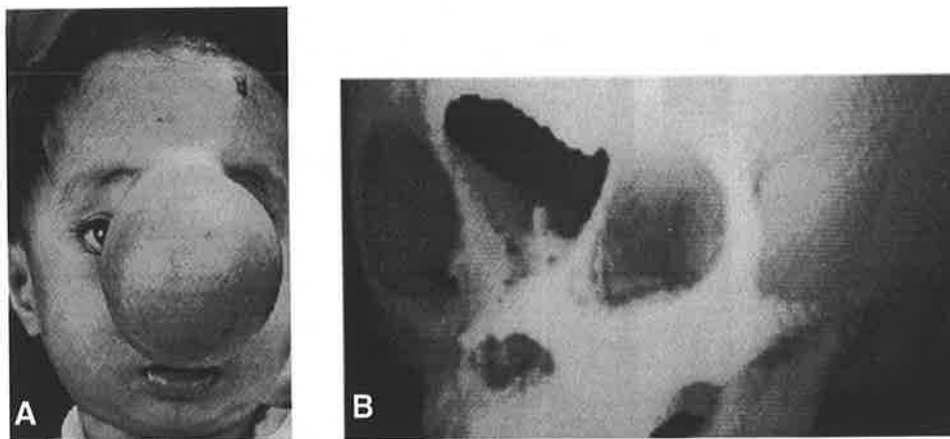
A. A large nasofrontal type of frontoethmoidal meningoencephalocele. B. Three-dimensional computed tomogram demonstrates the downward tilted cribriform plate with the crista galli forming the posterior margin of the cranial defect and the nasal bone forming the inferior margin of the facial defect. (From D. David et al. *Meningoencephaloceles: Classification, pathology, and management. Adv. Plast. Reconstr. Surg.* 5:85, 1989. Reproduced with permission.)
